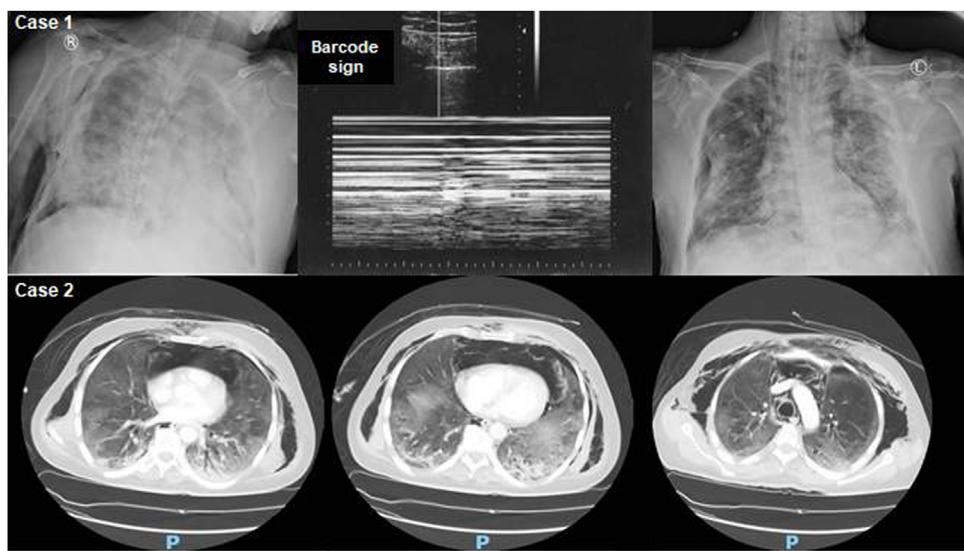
Upper panel (Case 1):* Chest X-rays showing right-sided pneumothorax, pneumo-mediastinum and subcutaneous emphysema (left) that was confirmed (barcode sign) by the M-mode of the lung ultrasound (middle) and resolution after chest drain insertion (right). *Lower panel (Case 2):* axial lung window views of chest computed tomography scans depicting bilateral peripheral ground-glass opacities, dependent air-space consolidations, small pneumothoraces, and pneumomediastinum with subcutaneous emphysema.
